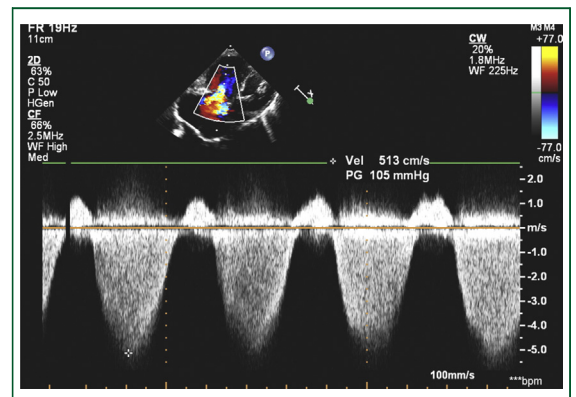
Doppler signal of hypertensive tricuspid regurgitation in a patient with severe mitral stenosis. The estimated pulmonary artery systolic pressure is 105 mm Hg.
